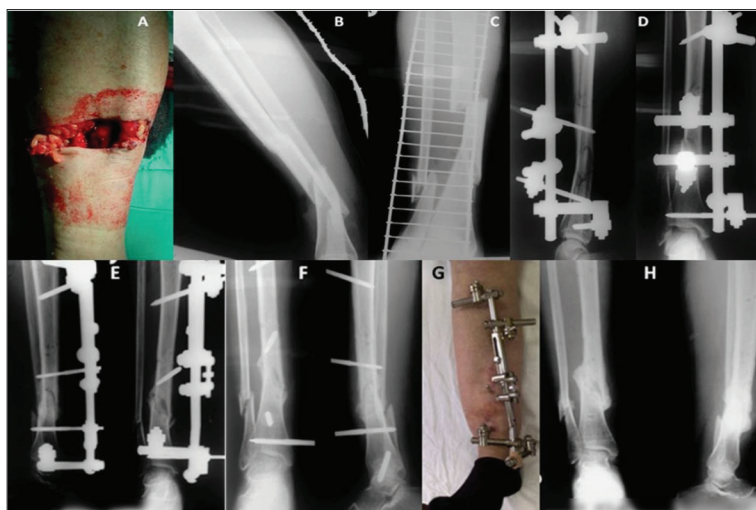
Open segmental tibial shaft fracture treated by external fixation method. A – Injured leg of the 27-year-old patient, injured in a traffic accident as a passenger on the motorcycle; B – X-ray after the injury (lateral view); C – X-ray after the injury (anteroposterior view); D – X-ray (lateral and anteroposterior view) after the external fixation; E – X-ray (lateral and anteroposterior view), four months after the injury; F – X-ray (anteroposterior and lateral view) varus and antecurvatum deformity was observed two weeks after the fixator frame removal; G – External fixator with V frame is installed for gradual angular deformity correction; H – X-ray (anteroposterior and lateral view) after deformity correction and after fixator removal, eight months after the injury [20]
